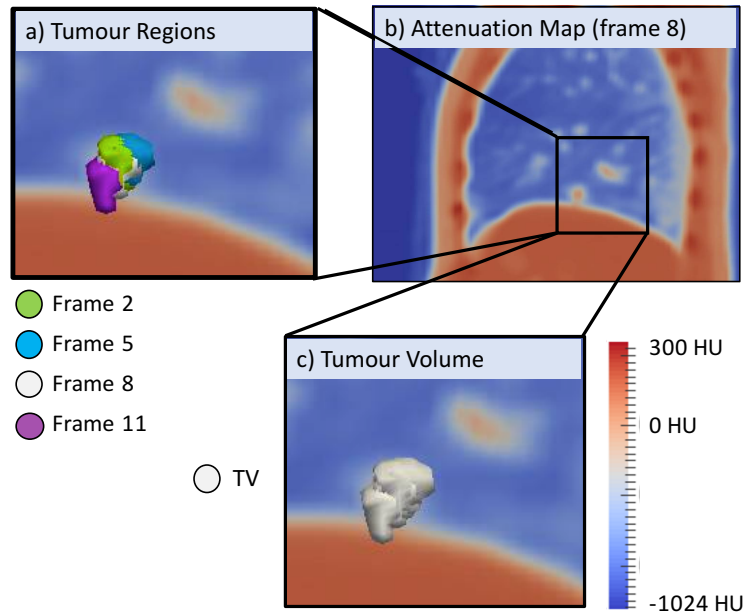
The segmented tumour in study 16 is superimposed on a coronal cross section of the attenuation map for PET/CT. Subfigure (b) shows the reference frame (frame 8) with no transform applied to the tumour or the attenuation map. Subfigure (a) shows the deformed tracking region for frame 2 (Green), frame 5 (Light blue), frame 8 (White) and frame 11 (Purple). Subfigure (c) shows the tumour volume (TV) extent which is a larger region that encapsulates the movement of the tumour over the entire respiratory cycle.
